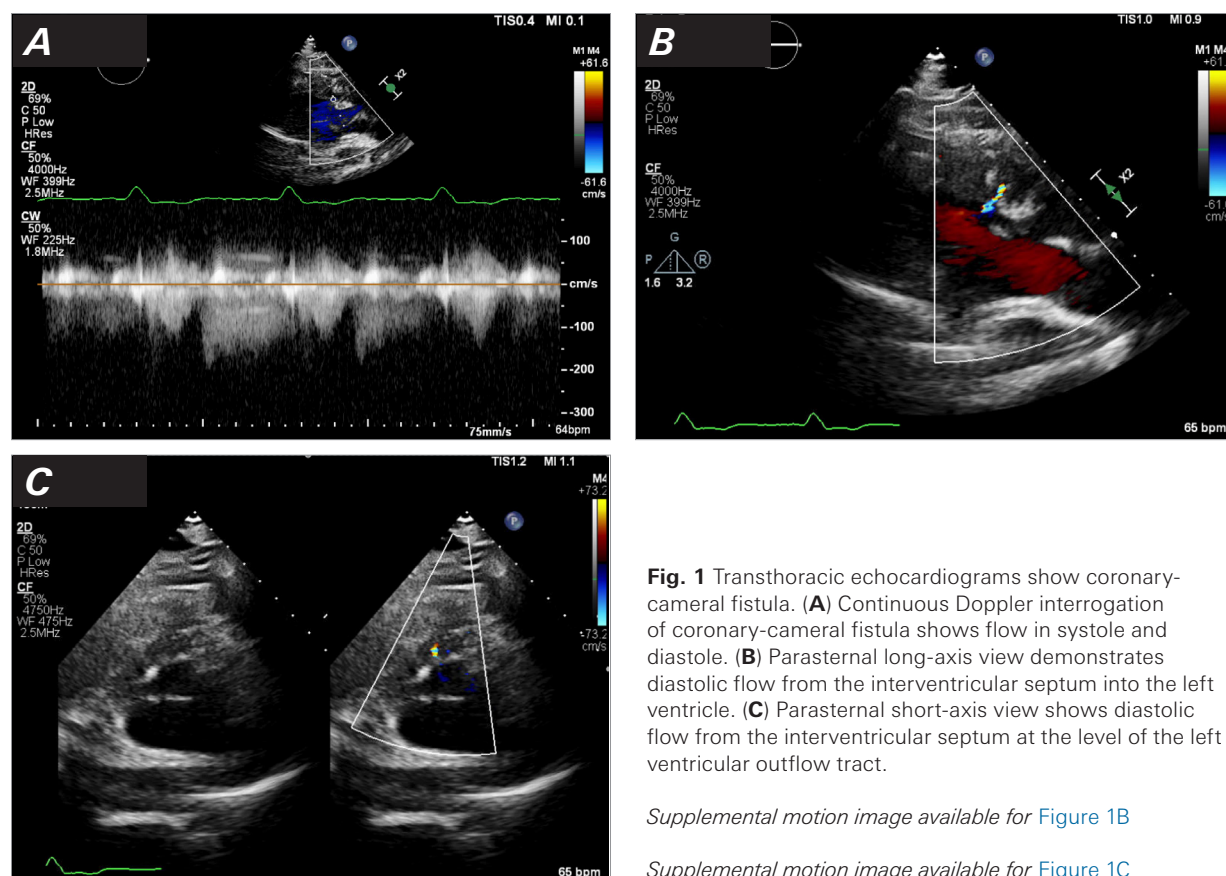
Transthoracic echocardiograms show coronary-cameral fistula. (A) Continuous Doppler interrogation of coronary-cameral fistula shows flow in systole and diastole. (B) Parasternal long-axis view demonstrates diastolic flow from the interventricular septum into the left ventricle. (C) Parasternal short-axis view shows diastolic flow from the interventricular septum at the level of the left ventricular outflow tract.
